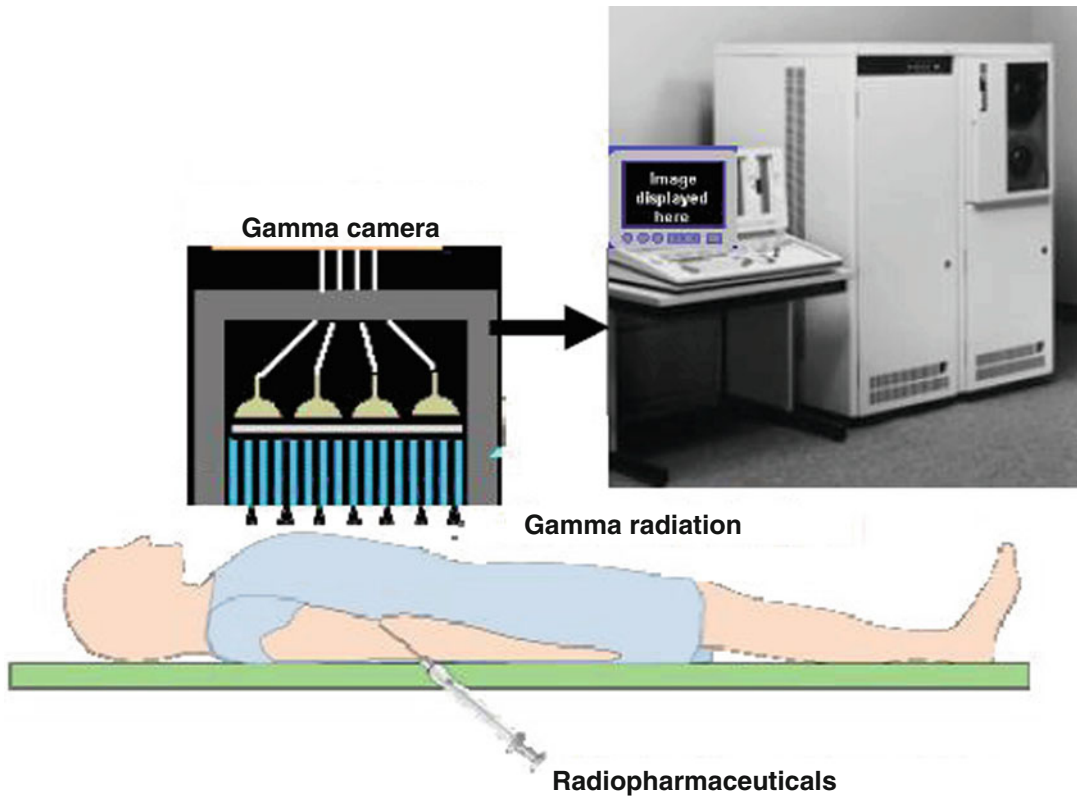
Single-photon emission computed tomography (SPECT)
